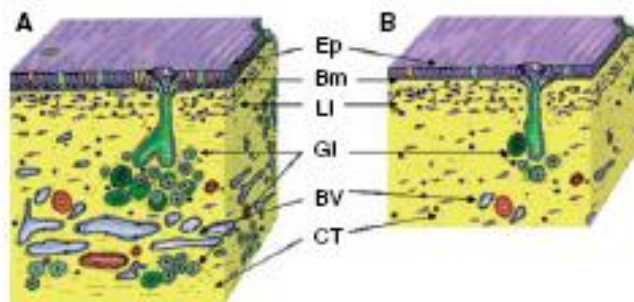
Histomorphological view of normal (A) nasal and (B) paranasal mucosa (Ep: epithelial cells; Bm: basement membrane; L1: lymphoid layer; Gl: glands; BV: blood vessels; CT: connective tissue).
